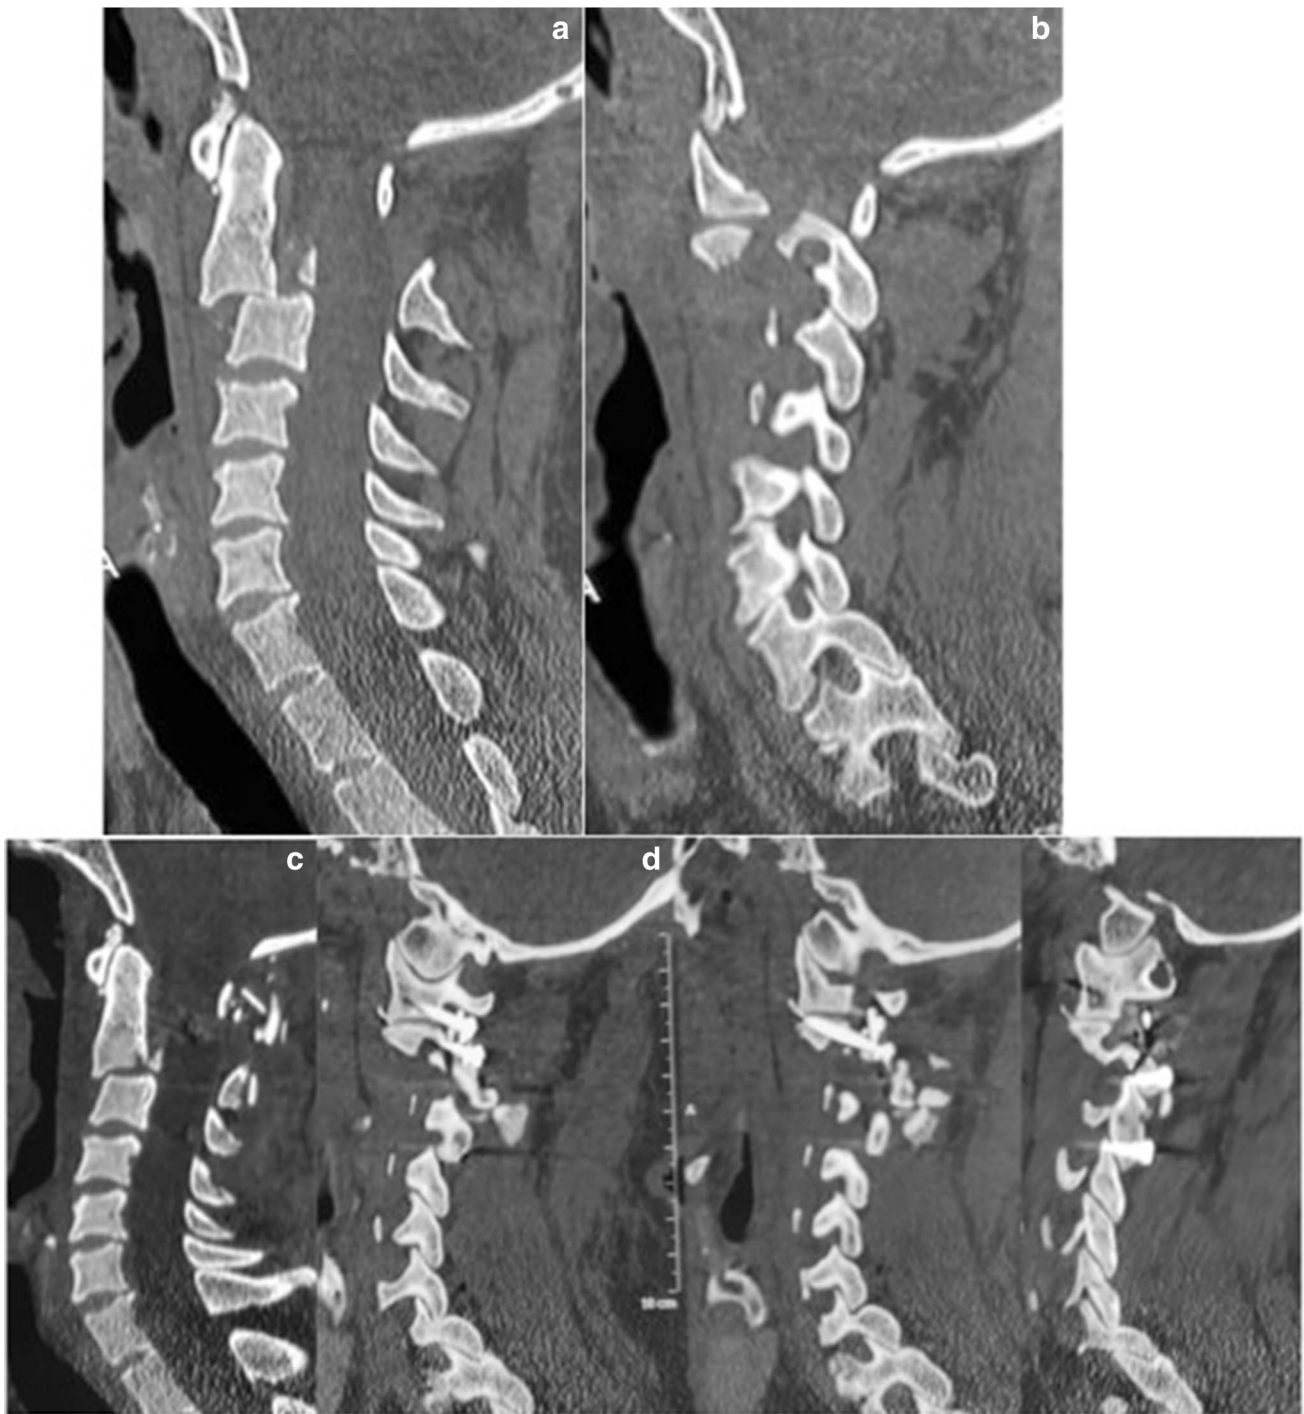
(Case no. 6) Images of a 25-year-old male patient. A: CT scan showing the C2–3 listhesis (type 4). B: CT scan showing the fracture and the distraction of fractured segments. Note the high vertebral
